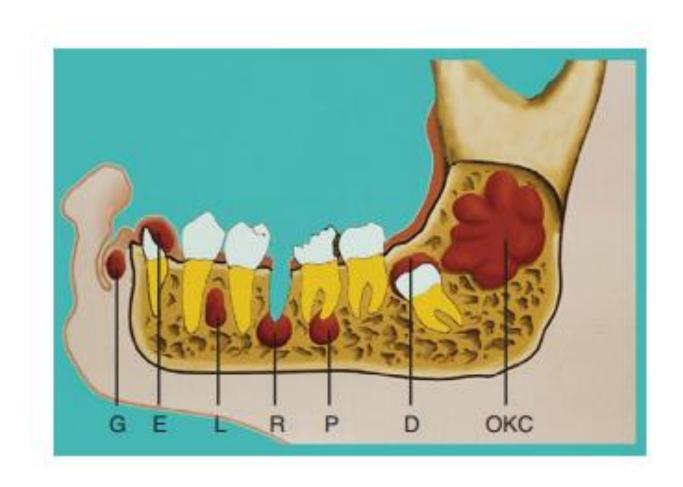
Odontogenic cysts based on typical clinical and radiographic features. Left to right: G, gingival; E, eruption; L, lateral periodontal; R, residual; P, periapical; D, dentigerous; OKC, odontogenic keratocyst. (McClatchey, 1979)
